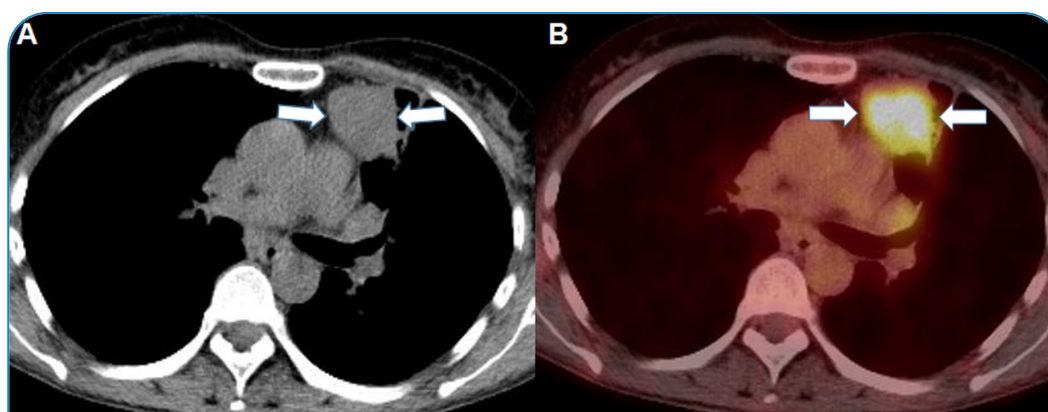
F-18 FDG PET/CT scan shows a lesion approximately 53 mm in size (arrow) with irregular borders in the anterior segment of the (A) left lung upper lobe and (B) an increased maximum standardized uptake value of 16.7. F-18 FDG PET/CT, 2-deoxy-2-[fluorine-18] fluoro-D-glucose positron emission tomography/computed tomography.
